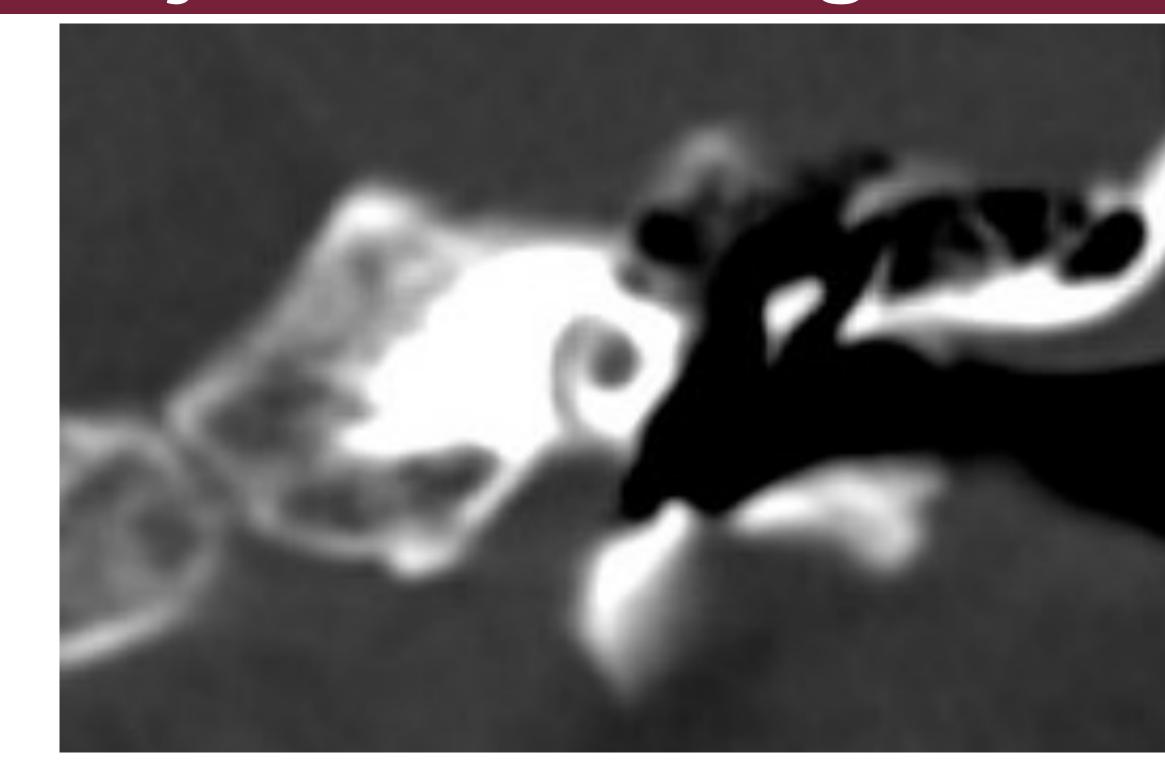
CTA Coronal Left Cochlea Carotid cochlear dehiscence located at the basal turn of the cochlea
